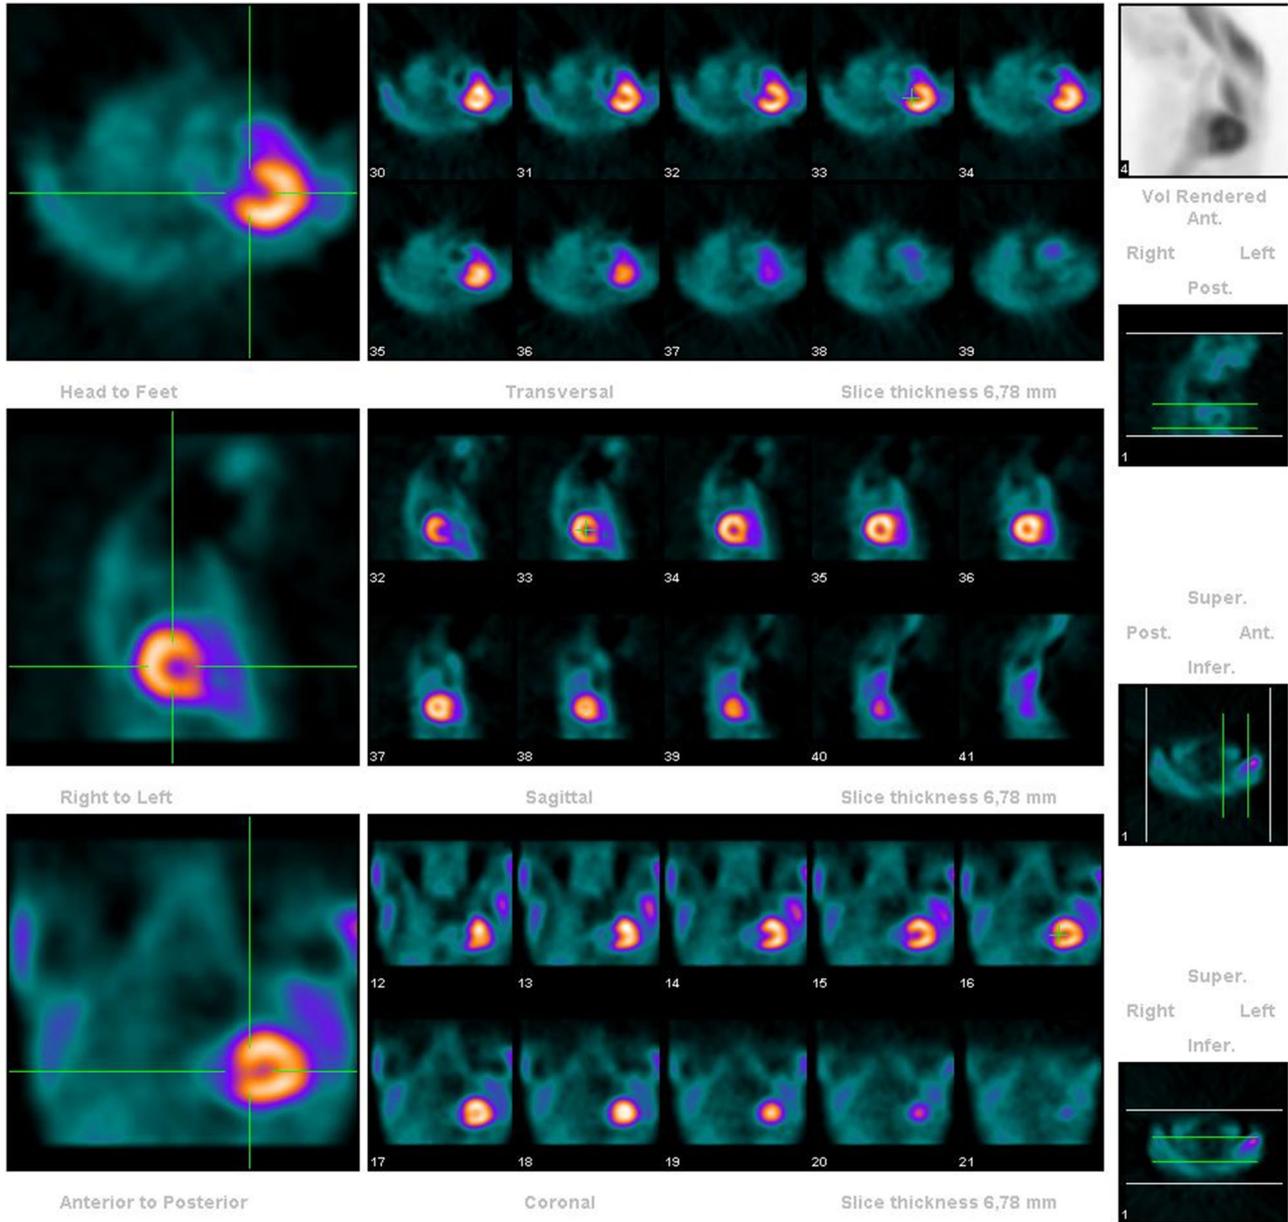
MPI SPECT showing the position of the heart in thorax.
